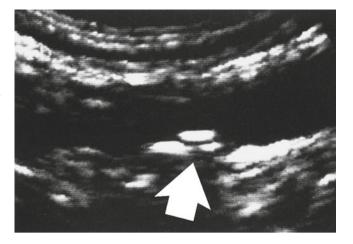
Duplex ultrasound image of the carotid artery showing homogeneous plaque (*arrow*)
